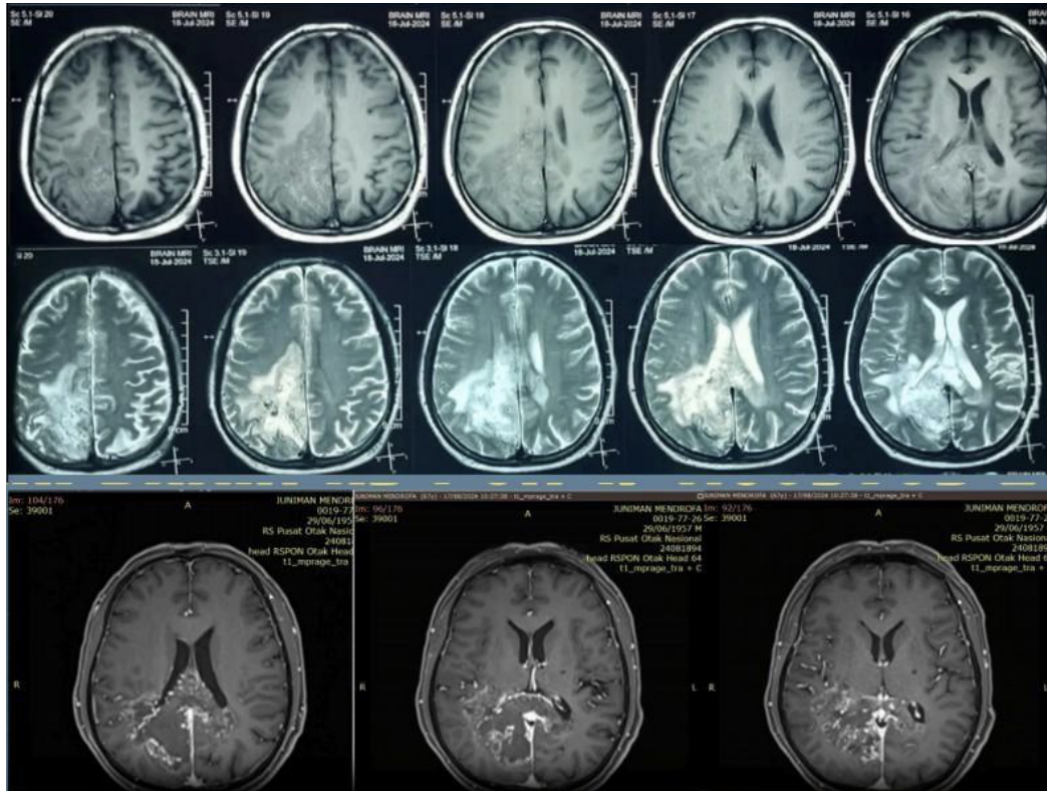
Brain MRI with contrast shows a lesion that is hypo- to hyperintense on T1, hyperintense on T2 and FLAIR, with hemorrhagic components and necrotic areas, accompanied by peritumoral edema.
